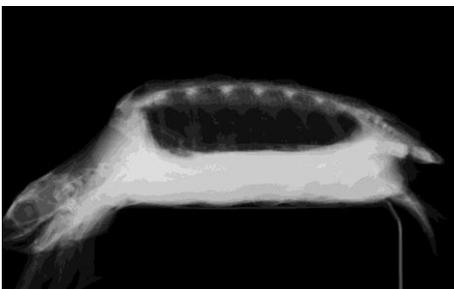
Lung X-ray in lateral projection in a healthy patient. It clearly shows a normal lung parenchyma, homogeneously radiolucent.
